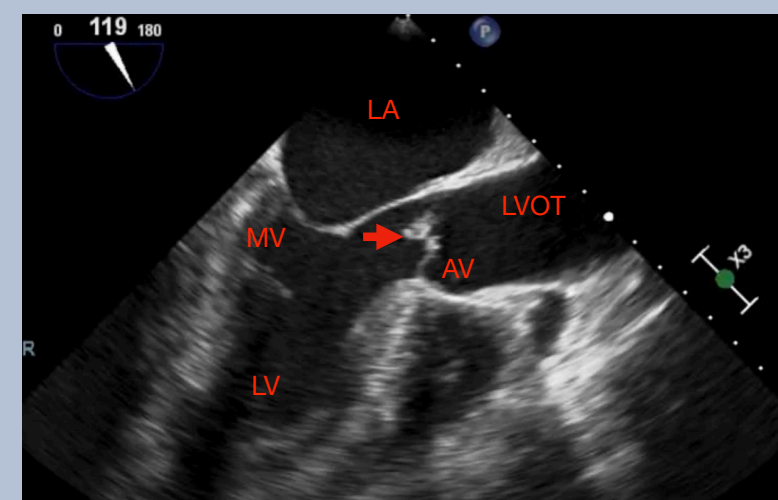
(left) - Transesophageal echocardiogram from Case 1 depicting aortic valve vegetation. Patient diagnosed via serology with associated pauci-immune glomerulonephritis. He was treated with doxycycline and rifampin but was lost to follow up.
